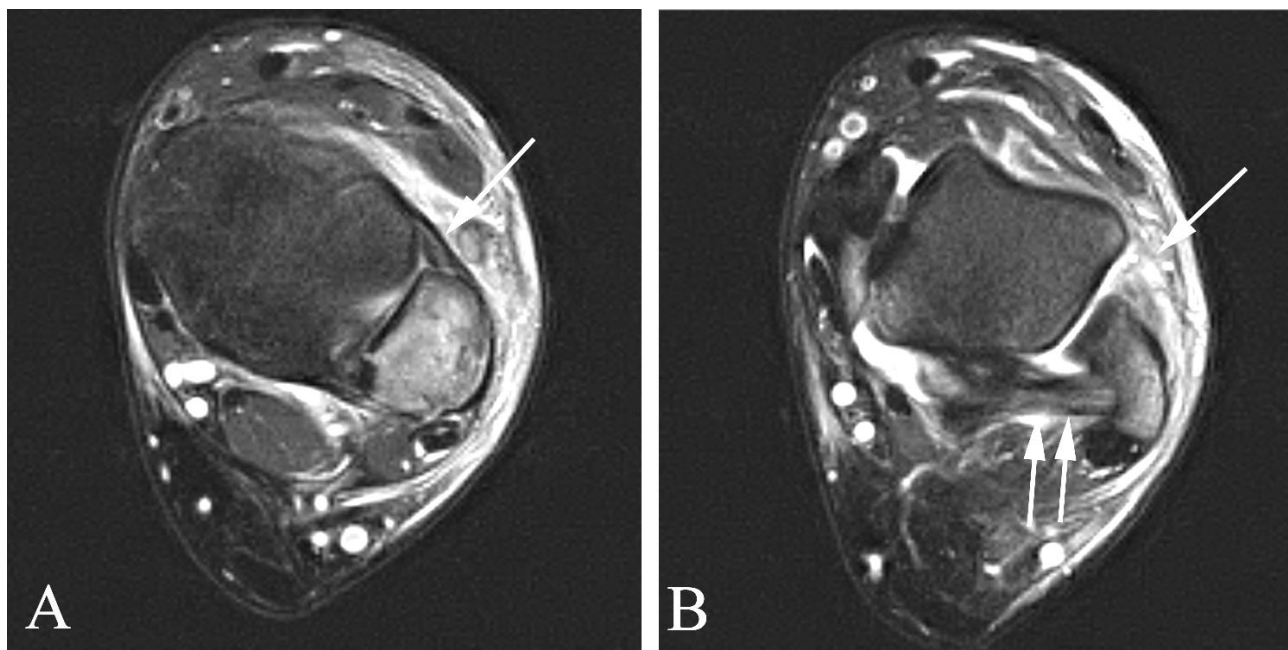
Ankle sprain (torn anterior talofibular ligament) in a 16 year old man with pain following trauma. A. Axial fat-suppressed proton density MR image shows a normal, intact distal syndesmotibial connection (the distal tib-fib ligament) spanning the anterior aspect of the distal tibia and fibula (arrow). B. Axial fat-suppressed proton density MR image slightly inferior shows an intact posterior talofibular ligament (double white arrow). At the usual position of the anterior talofibular ligament, there is ill defined increased soft tissue density (arrow) without definition of the ligament itself, characteristic of a full thickness anterior talofibular ligament tear.
